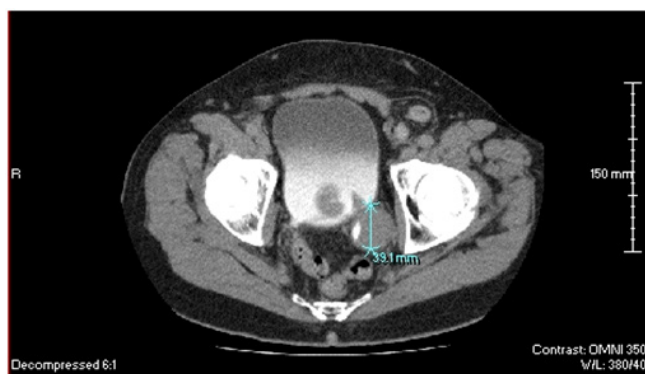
A CT scan of the pelvis at the time of presentation (2-19-2010). It shows a mass at the left posterior ureterovesical junction that measured 39.1 mm in its widest diameter. The patient began taking Salicinium, a plant derived compound reportedly selectively toxic for tumor cells.
